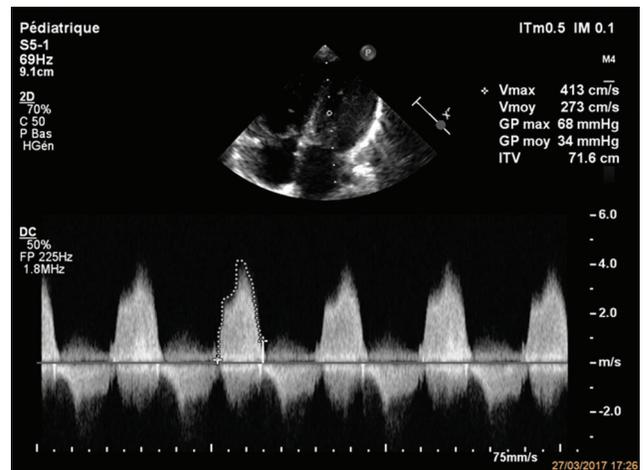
Continuous wave Doppler on the mitral valve evaluating the elevation of the mitral gradient
